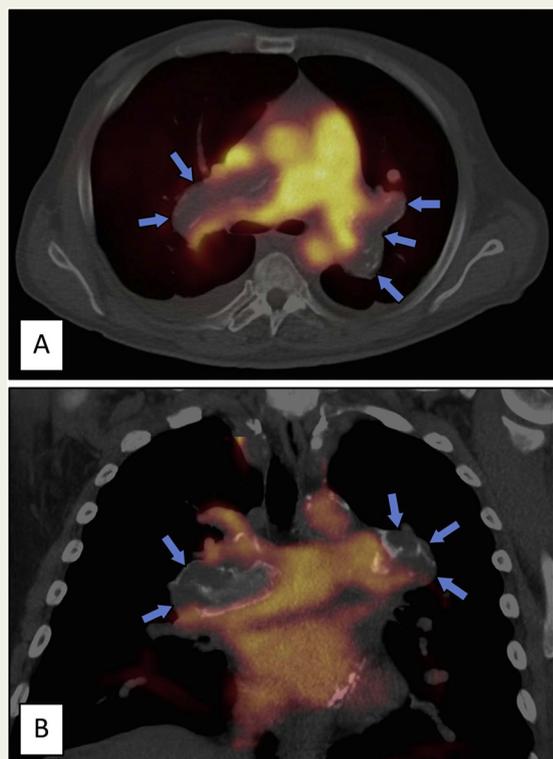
A/B Axial/coronal FDG-PET/CT of the mid thorax, early dynamic positron emission tomography (PET) acquisition (20–45 seconds after intravenous injection of F-18-fluorodeoxyglucose). The partially missing tracer flow within the dilated central pulmonary arteries indicated non-occlusive bilateral central thromboemboli in the severely dilated pulmonary arteries (blue arrows). PET angiography confirmed that the mass-like hilar enlargements were caused by vascular ectasia.
